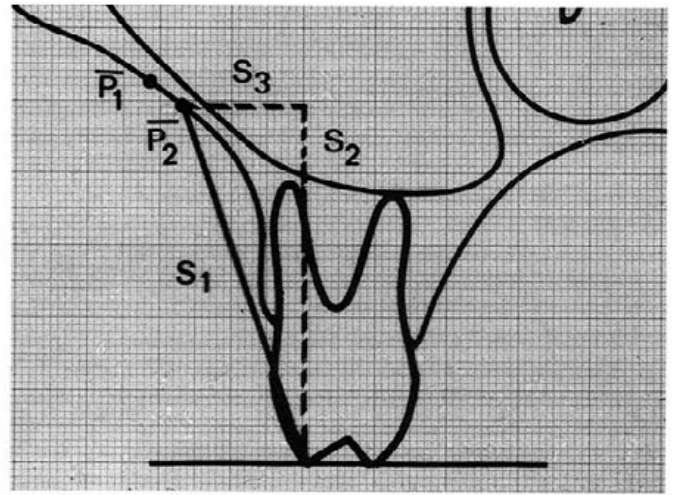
Transfer of the planned reference lines and end points for measurement and calculation of the discrepancy  $S_2$  minus  $S_1$ , corresponding the lateral radiograph on the contour lines.
